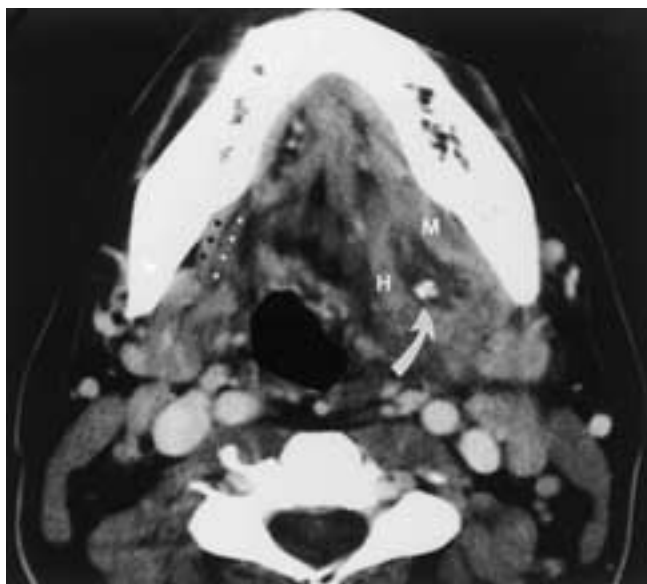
Submandibular gland duct calculus with abscess and duct obstruction. Axial contrast-enhanced CT scan demonstrates a calculus with surrounding hypoattenuating fluid density material (pus) (*arrow*). There is significant surrounding edema and a mass effect. Myositis of the left hyoglossus (H) and mylohyoid (M) muscles is identified compared to the normal contralateral mylohyoid (*black dots*) and hyoglossus (*white dots*) muscles.
